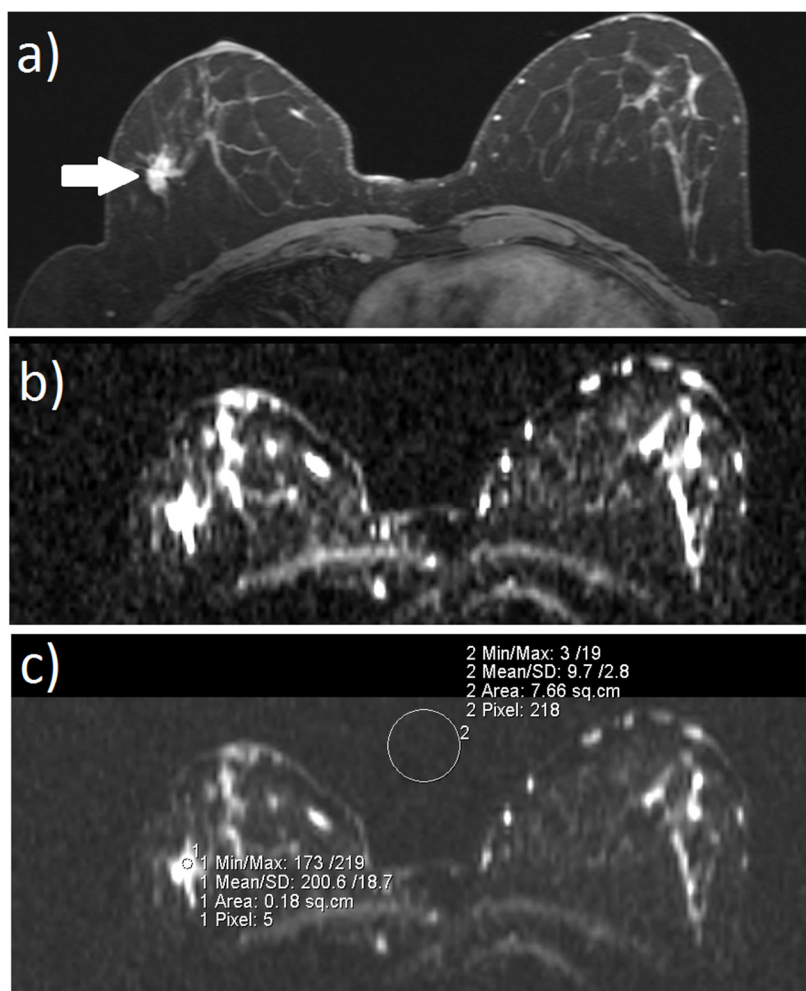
a) The white arrows shows the lesions in DCE-MR image. b) The $b=0 \text{ s/mm}^2$ DW image. Lesions can be seen in left breast of the figure as bright spot. c) With circular tool ROI is drawn carefully inside the lesions and into the background, outside the patient.
